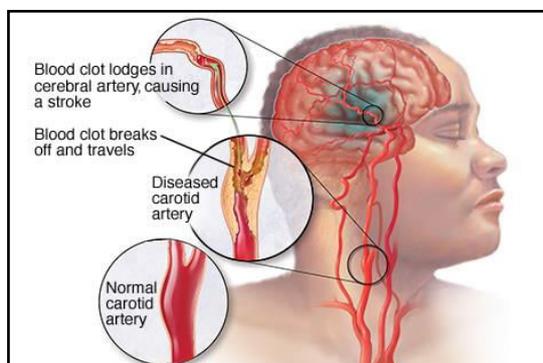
Stroke reason and imaging in MRI
